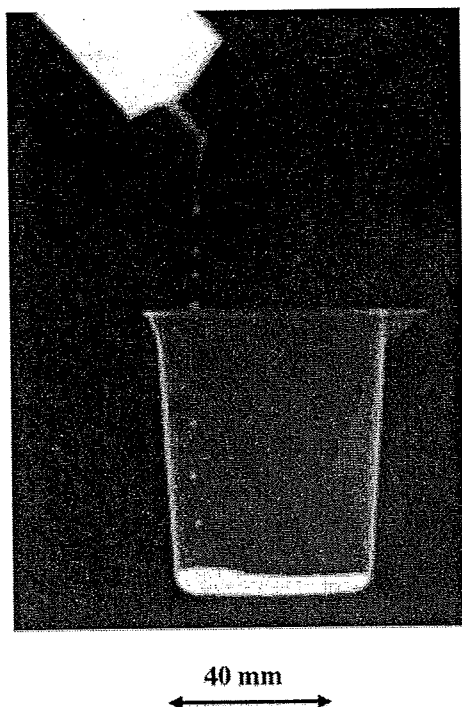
Radiogram of water spouted from an injector. The stop-motion image of water was obtained by monochromatic flash radiography.
